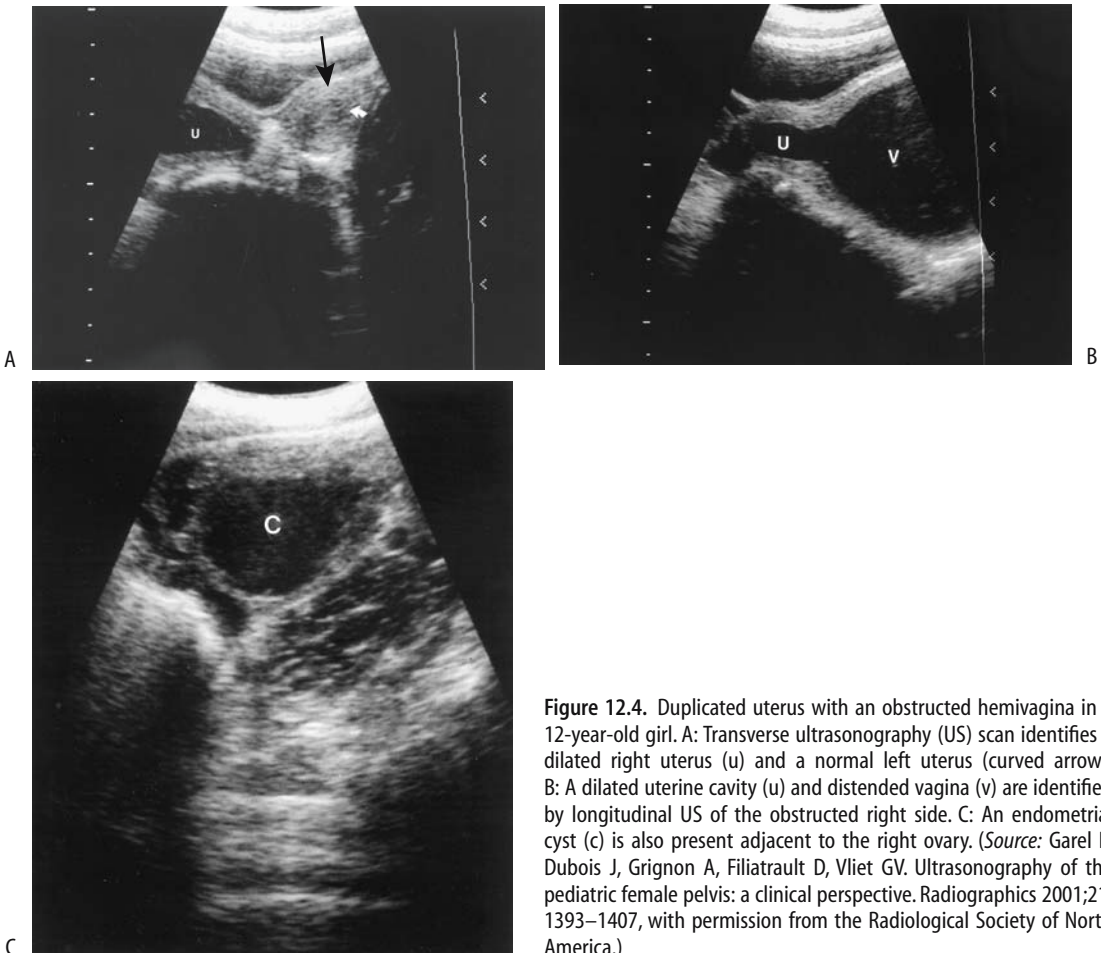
Duplicated uterus with an obstructed hemivagina in a 12-year-old girl. A: Transverse ultrasonography (US) scan identifies a dilated right uterus (u) and a normal left uterus (curved arrow). B: A dilated uterine cavity (u) and distended vagina (v) are identified by longitudinal US of the obstructed right side. C: An endometrial cyst (c) is also present adjacent to the right ovary. (Source: Garel L, Dubois J, Grignon A, Filiatrault D, Vliet GV. Ultrasonography of the pediatric female pelvis: a clinical perspective. *Radiographics* 2001;21:1393–1407, with permission from the Radiological Society of North America.)
